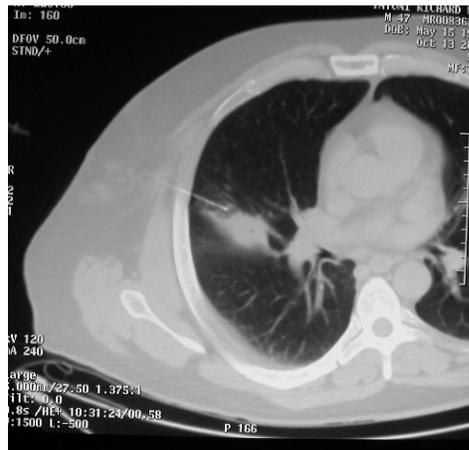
The CT scan-guided aspiration fine-needle is on target.
